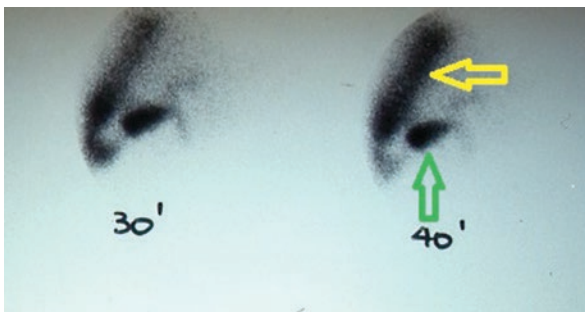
DIDA scan at 30 and 40 min in a patient that presented with a sudden onset of generalised abdominal pain after a 3-day history of prolonged typical biliary pain. An ultrasound confirmed acute cholecystitis with a large amount of free intra-abdominal fluid. The DIDA scan demonstrated the gallbladder (green arrow) with leakage of a large amount of bile into the peritoneal cavity (yellow arrow). Emergency LC revealed a free perforation of a gangrenous gallbladder
